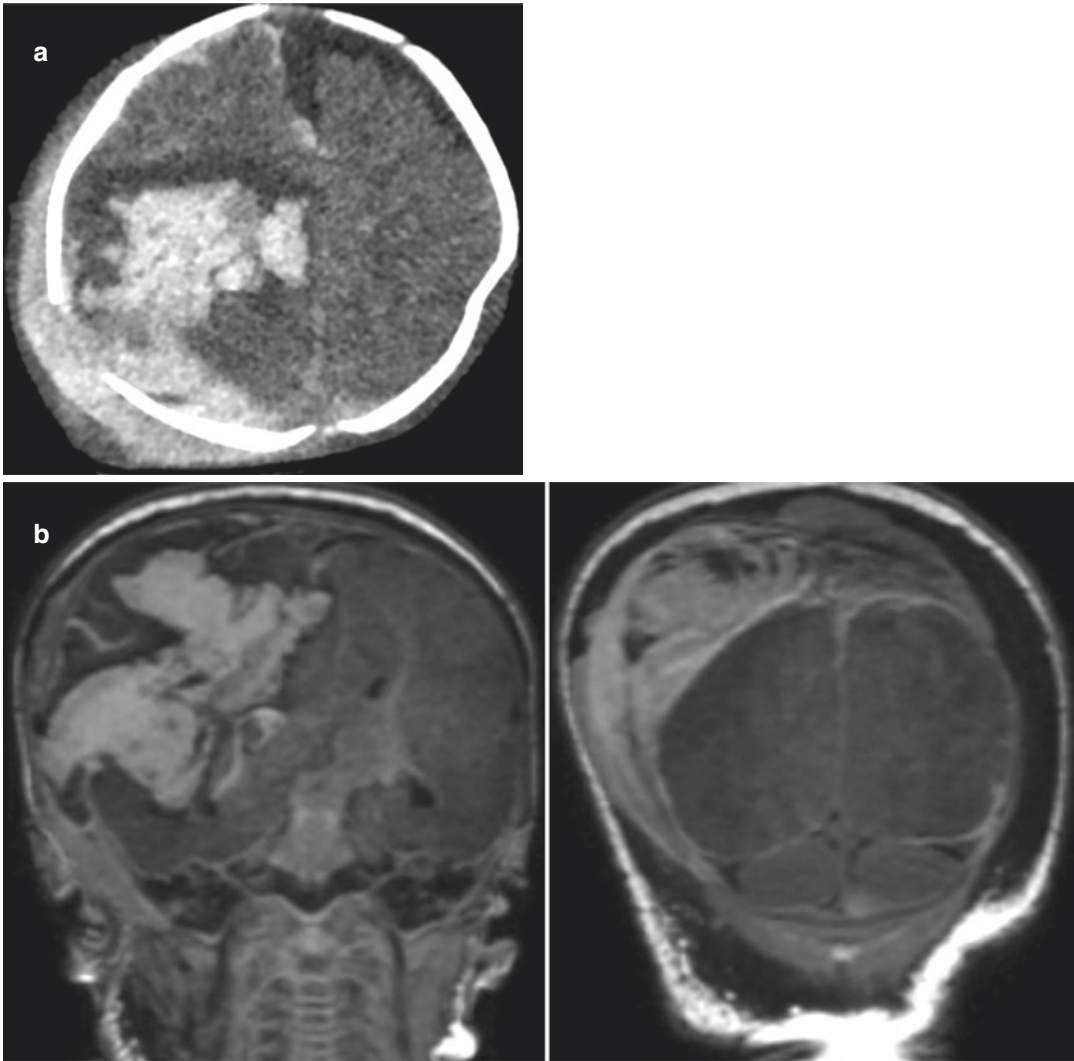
(a) Axial CT scan of the brain. (b) Coronal FLAIR sequence of the brain
